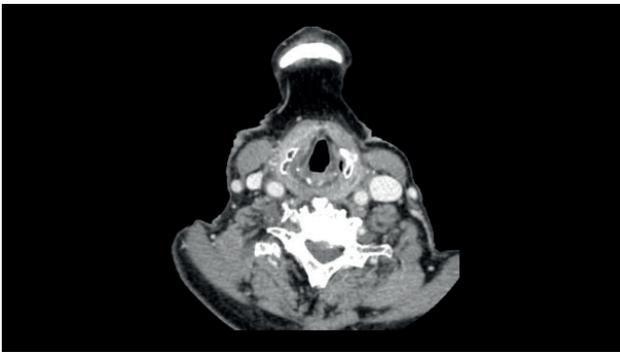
In the control CT scan of the neck with contrast the right parotid gland was smaller and the fluid collections within the parapharyngeal right space were significantly decreased.
